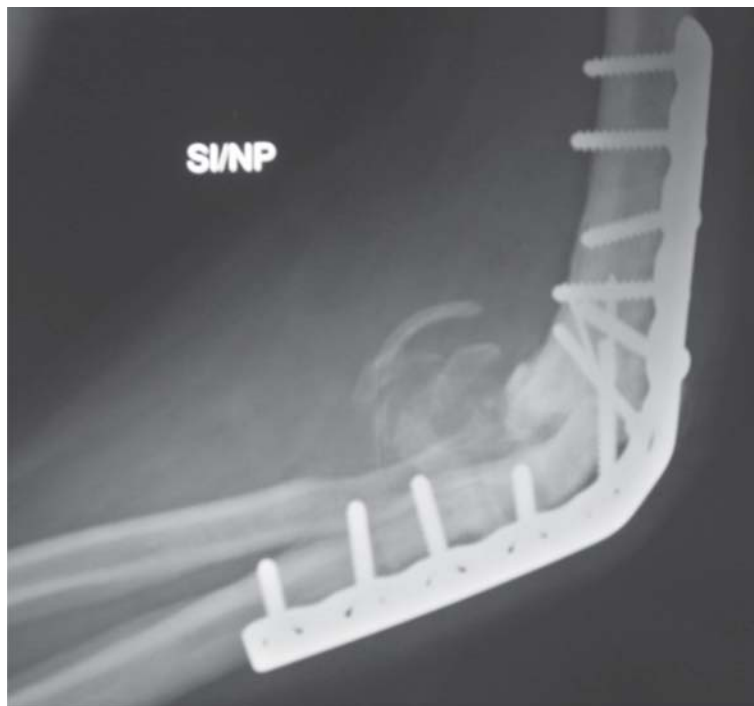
Post -operative X-ray showing elbow fusion.
